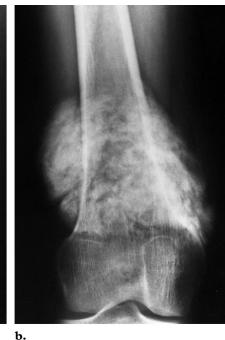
Parosteal osteosarcoma in a 24-year-old woman with a posterior knee mass. Lateral (a) and anteroposterior (b) radiographs of the thigh show a densely ossified mass arising from the posterior cortex of the distal femur. (Reprinted, with permission, from reference 51.)
